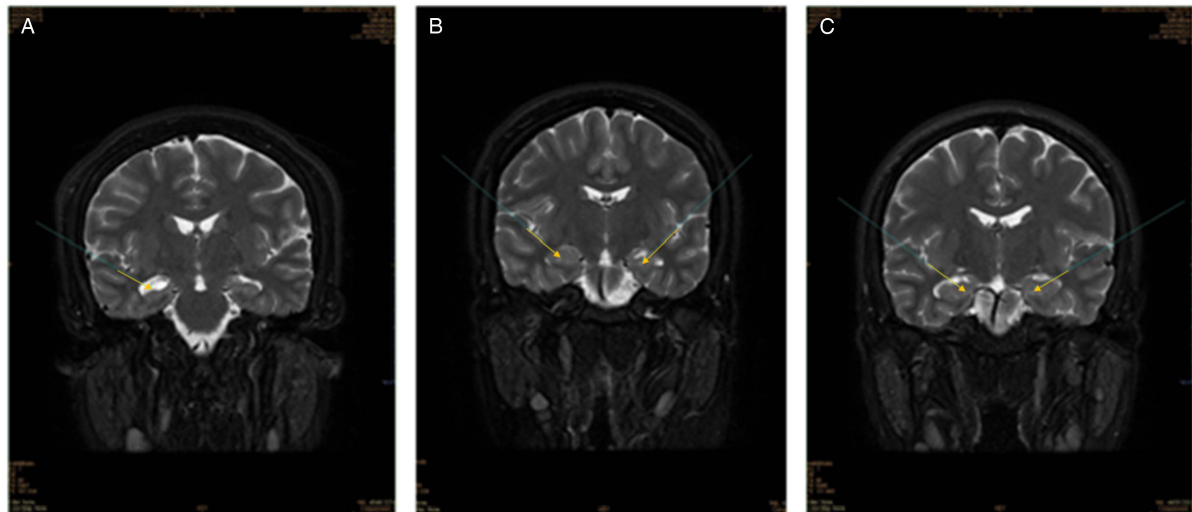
Patient A (panel A) shows non-contrast brain MRI of 16-year-old male with decreased right hippocampus volume; Patient B (panel B) is significant for bilateral increase of the hippocampal fissure size and smaller left hippocampus of a 17-year-old subject. Patient C (panel C) shows the non-contrast structural brain MRI of the brain pertinent for bilateral prominence of hippocampal fissures.
